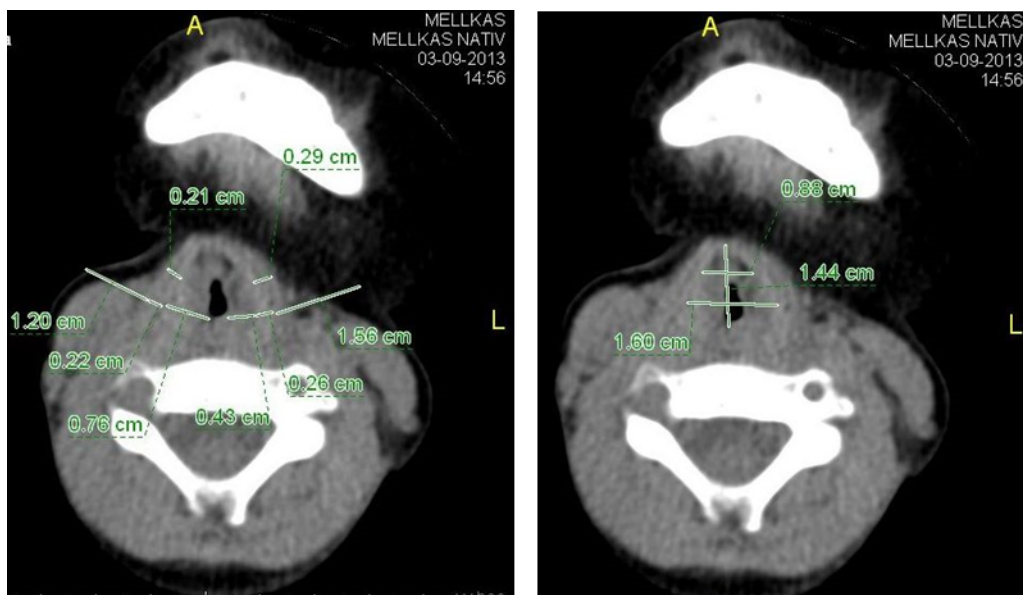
Representative CT image of a 20 month old infant, with measurements points.
